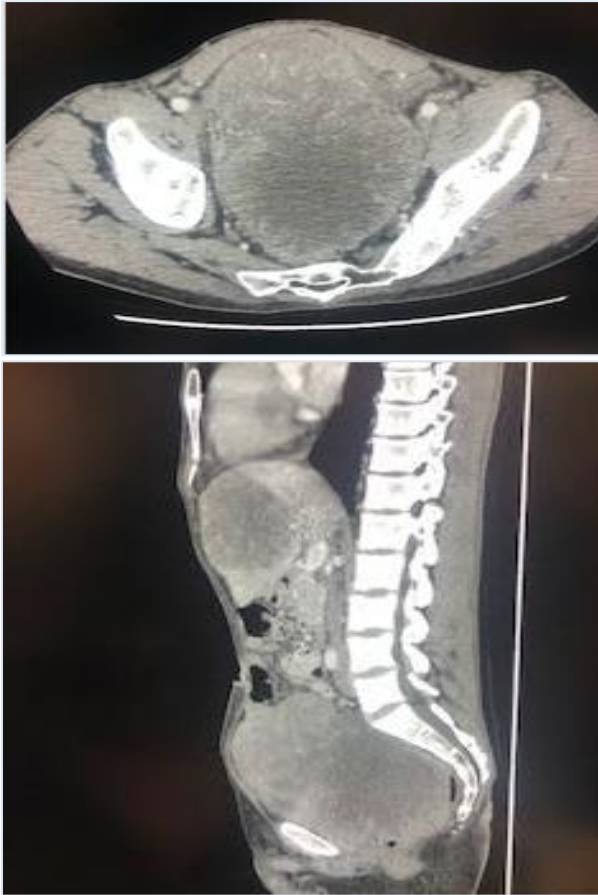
Abdominopelvic CT scan showing the prostate tumor invading the bladder. (Cross / sagittal section).
